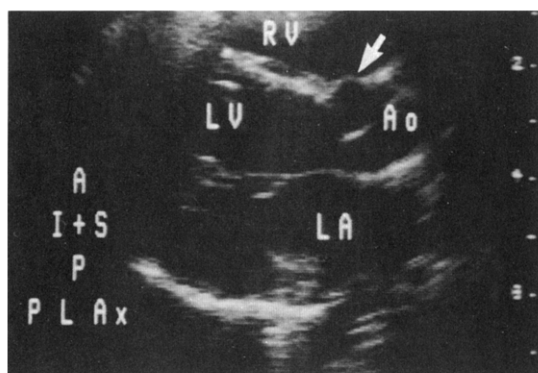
Patient 48. Apparent intact septum in a 3 year old patient with a doubly committed subarterial ventricular septal defect. This parasternal long-axis view (PLAX) shows discrete aortic (Ao) valve herniation. During diastole the ventricular septum seems to be intact. Only a discrete irregularity in the shape of the anterior aortic sinus (arrow) indicates its herniation into a ventricular septal defect. Other abbreviations as in previous figures.
